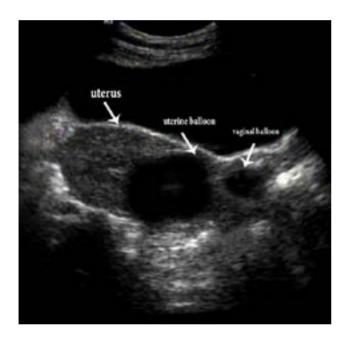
Ultrasonographic appearance of NDBCT after intrauterine insertion
